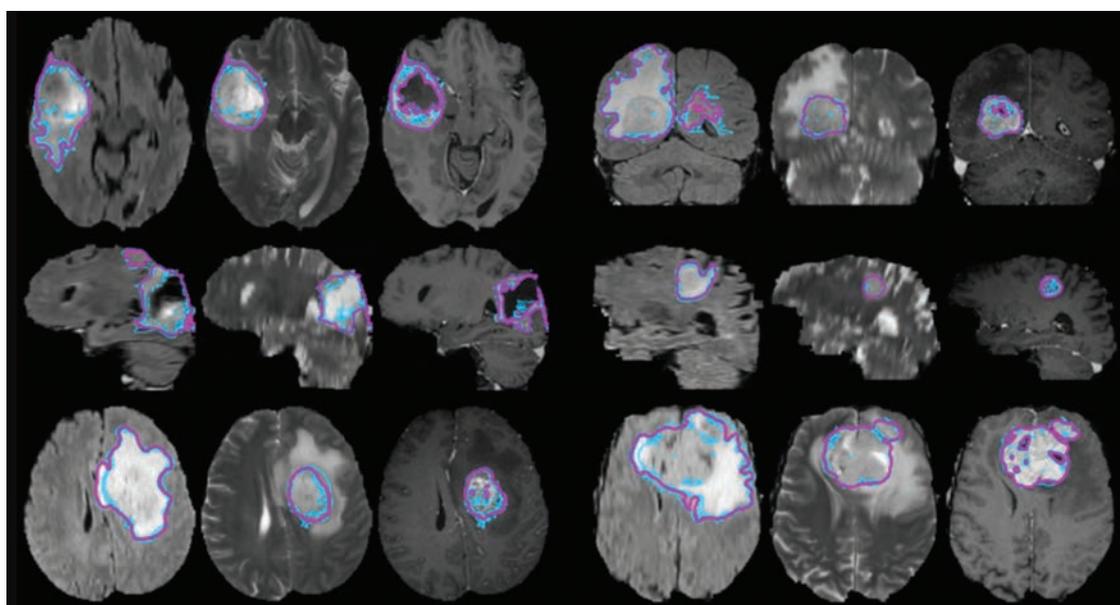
MRI brain samples from BraTS dataset.
